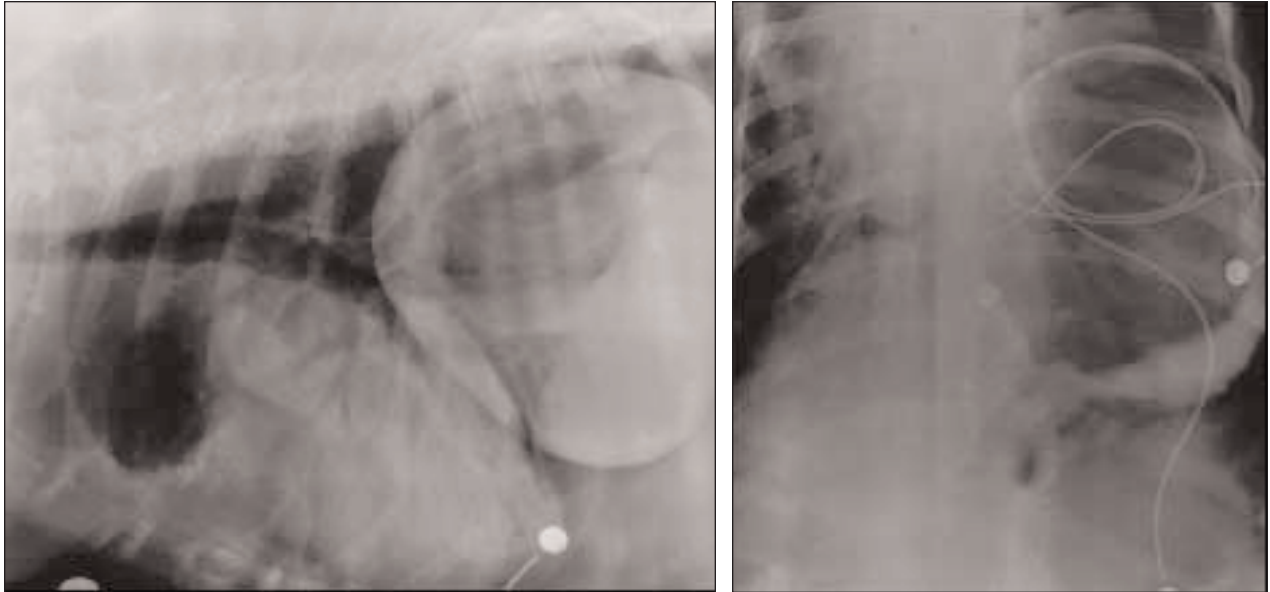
Right lateral (left) and dorsoventral (right) radiographic views of the thorax of a 9-year-old Great Dane with increased respiratory effort and lethargy that developed 24 hours after surgical treatment of gastric dilatation-volvulus.
